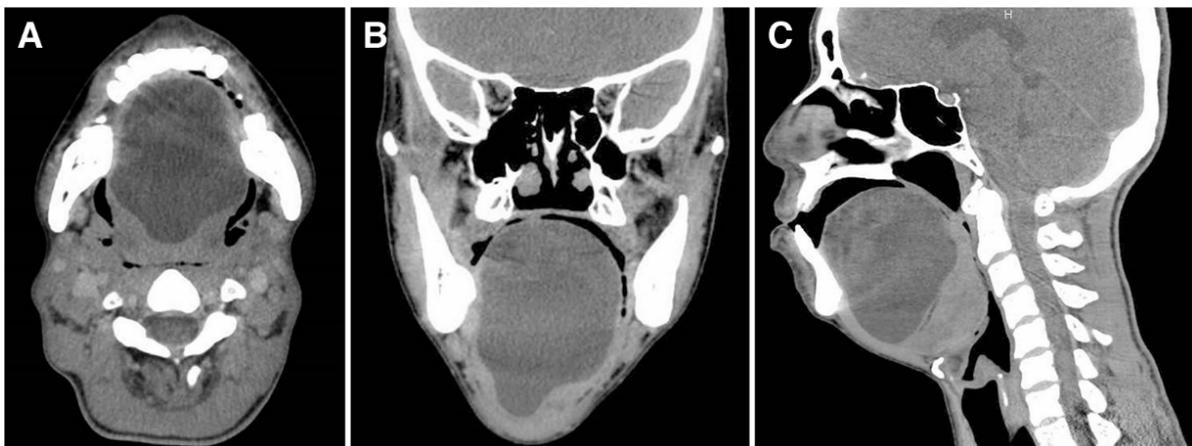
CT findings. (A–C) A well-defined cystic lesion with a maximum diameter of 75 mm was found on the mylohyoid muscle.
